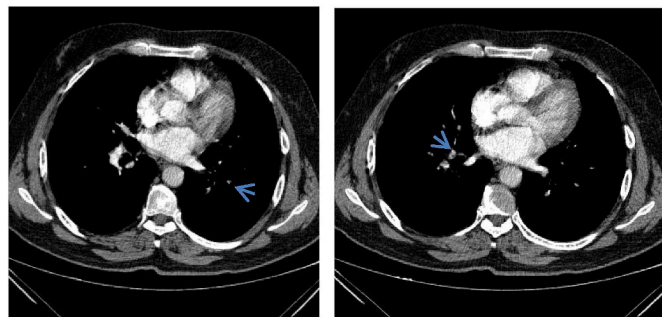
51-year-old man with 1 months of dry awakening cough. CT pulmonary angiography shows pulmonary emboli with obliteration in bilateral lower lobe artery (arrows in A and B).
